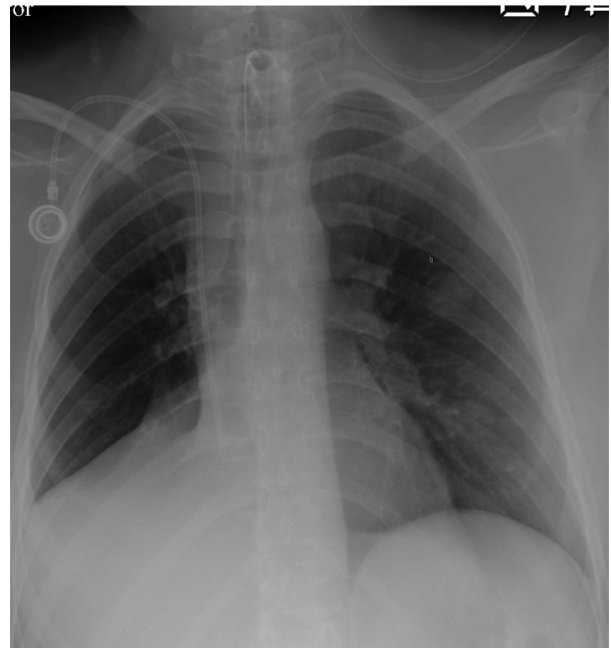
A frontal chest X-ray investigation 1 week after decannulation from ECMO. The right lower lobe lung necrosis is still persistent. The ECMO cannula has been removed, whilst the tracheal cannula and port-à-cath still are in place.
